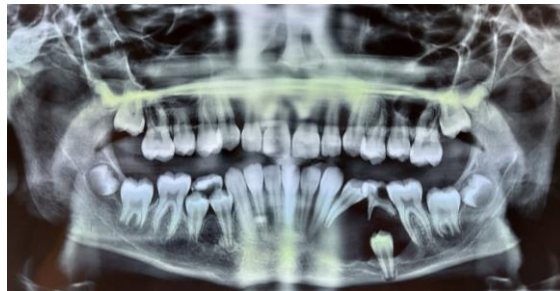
Panoramic radiograph: Well-limited radiolucent area surrounding the crown of the 35 tooth impacted and displaced at the basilar margin of the mandible
